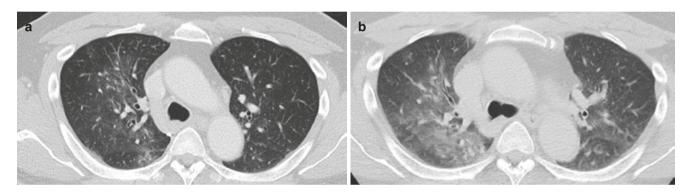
Parenchymal lung disease (hemorrhage). (a) Inspiratory CT image shows the similar caliber of vessels in lucent as well as gray areas. (b) Expiratory CT image shows increased density and decreased volumes in both lucent and gray areas
